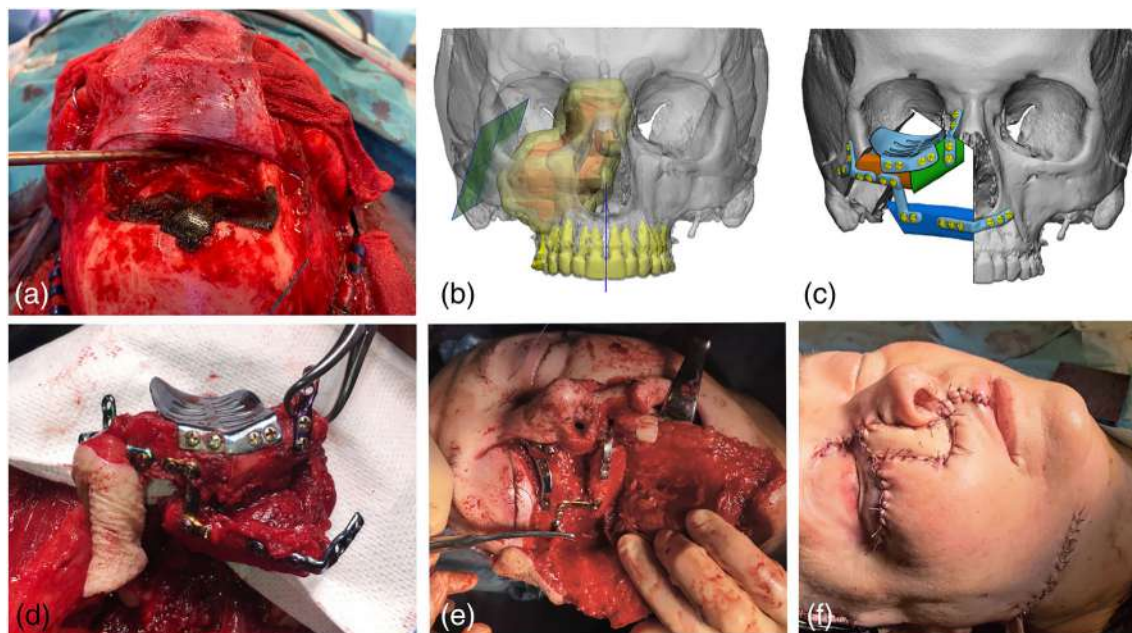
(a) Frontal craniotomy using bicoronal approach allowed access to the superior part of the tumor. (b) 3D reconstruction of the tumor volume obtained from the fusion of MRI and CT data. The orange color manifested the actual volume of the tumor and the yellow color showed 5 mm resection margin. (c) VSP of the case, including the patient's specific implants: four miniplates and one orbital floor reconstruction plate. (d) Actual configuration of the fibula flap before in-setting. (e) Intraoperative photo after the inseting of the flap. (f) Immediate postoperative photo
